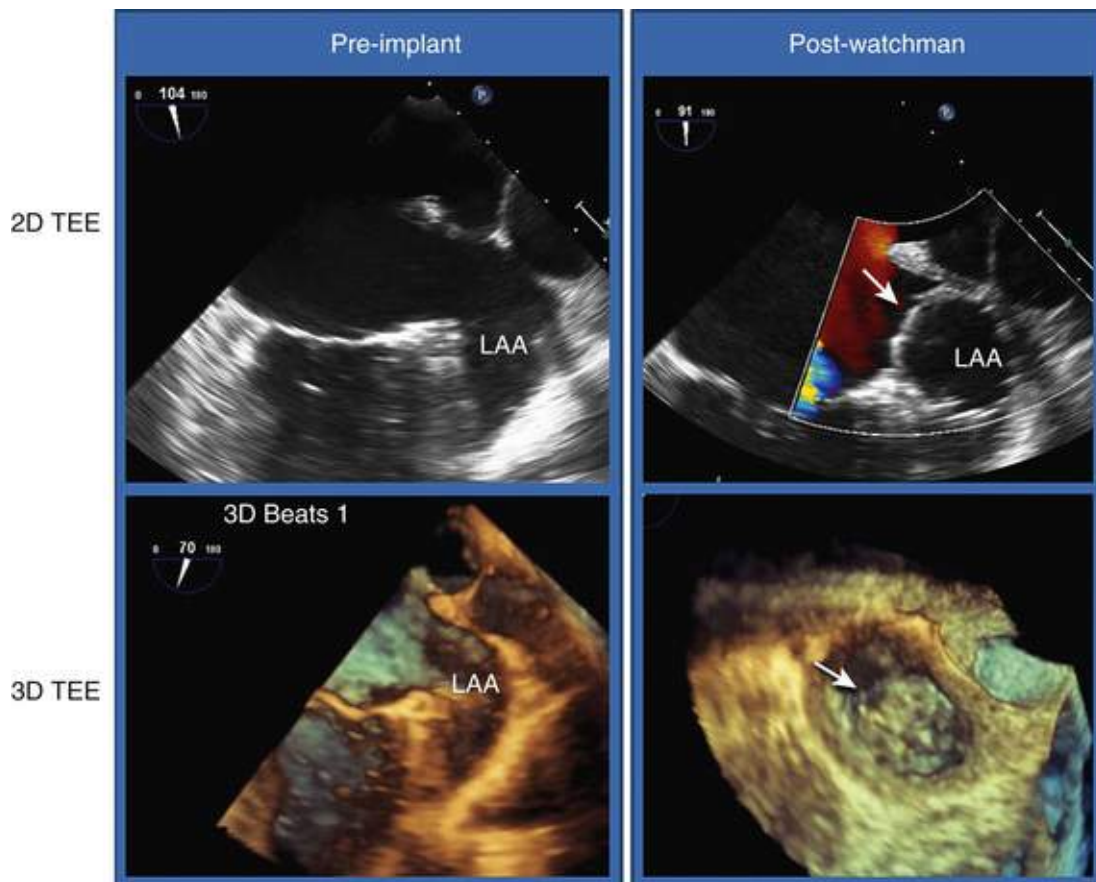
The Watchman device to occlude the left atrial appendage (LAA) for stroke prevention. Left panels, 2D and 3D TEE views of the LAA before implantation. Measurements of the LAA ostia taken at multiple angles for selection of the appropriate Watchman device. The appendage length must be longer than its width to accommodate device implantation. Right panels, Appendage occluder device (*arrow*) well seated at the neck of the appendage, with no residual flow around the device by color Doppler; top panel, 2D view; bottom panel, 3D en face view).
